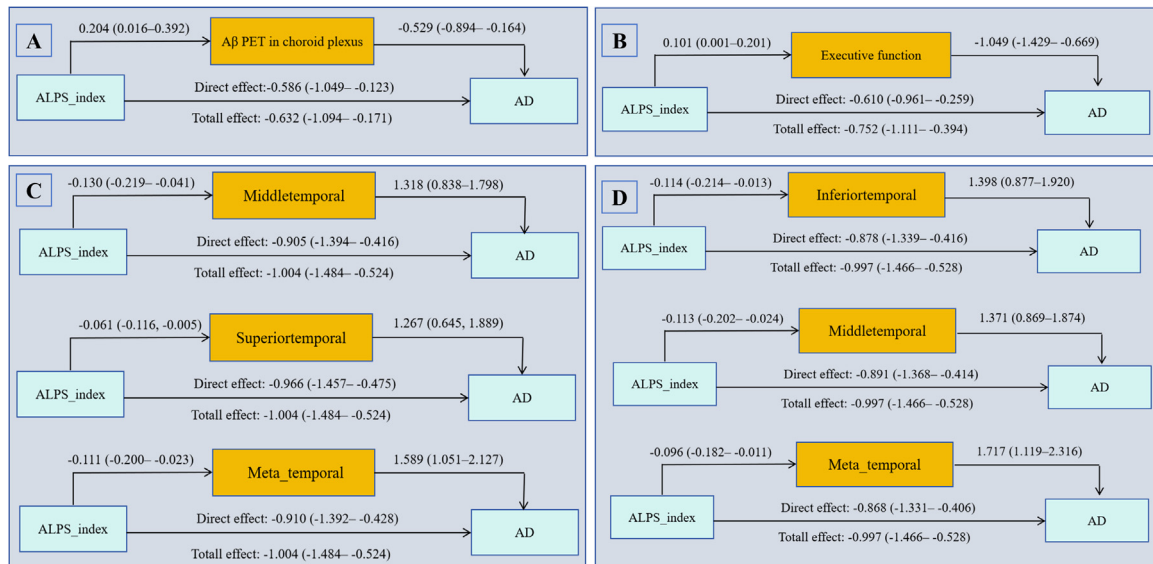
Mediating effects of PET SUVR and executive function on the association between ALPS index and incident AD in MCI cohort during follow-up. A: Mediator factor is A β PET in choroid plexus. B: Mediator factor is Executive function. C: Mediator factor is AV1451 PET SUVR. D: Mediator factor is FTP PET SUVR.
